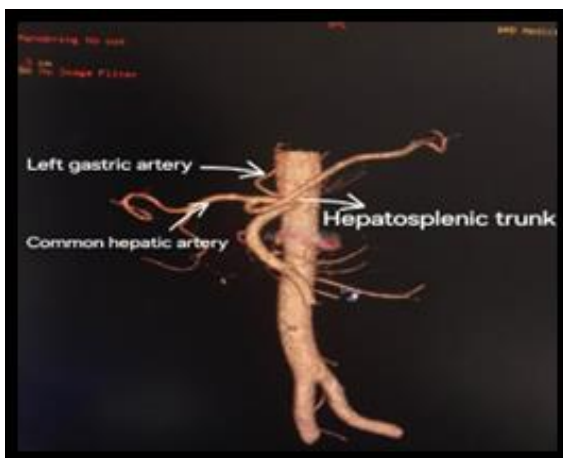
Computed tomography arterial phase images showing left gastric artery branching directly from abdominal aorta (Uflacker's type II)
